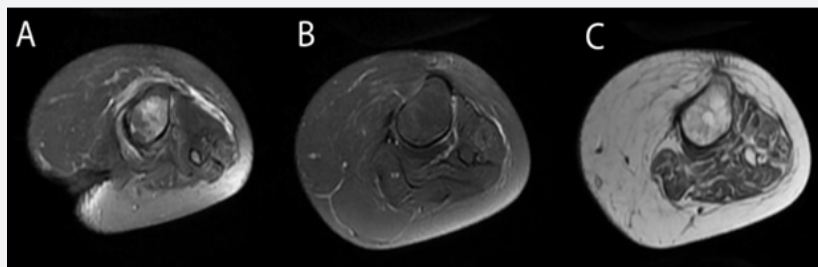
Left Lower Extremity on MRI Cross-Section A) AX T2 with FS; B) AX T2 with FS; C) AX T1.
